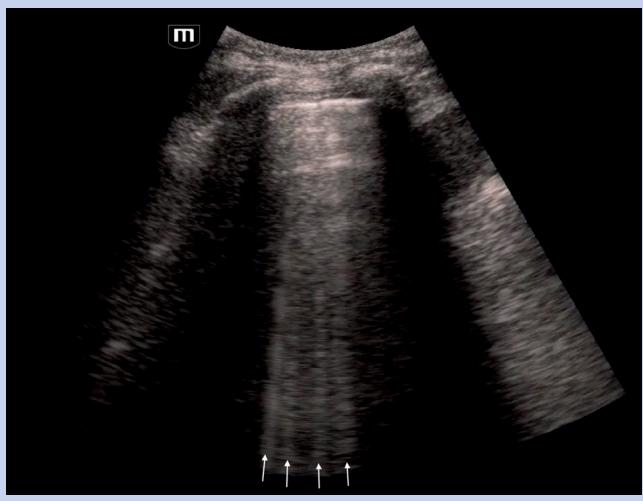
B-lines (white arrows) on point-of-care cardiac ultrasound suggestive of pulmonary edema
